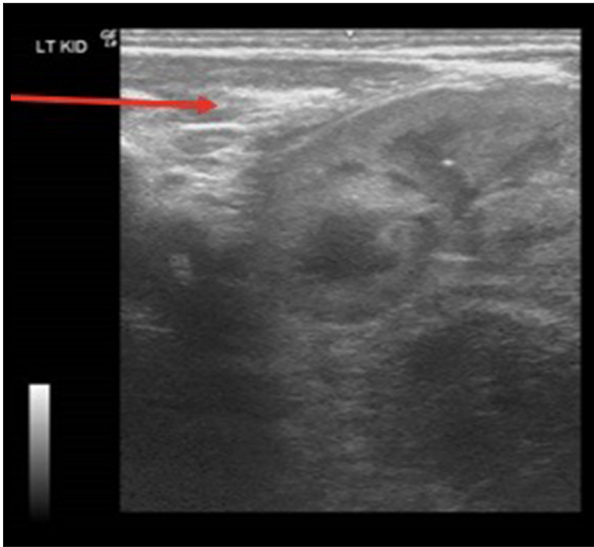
Abdominal ultrasound shows non-visualized spleen.
